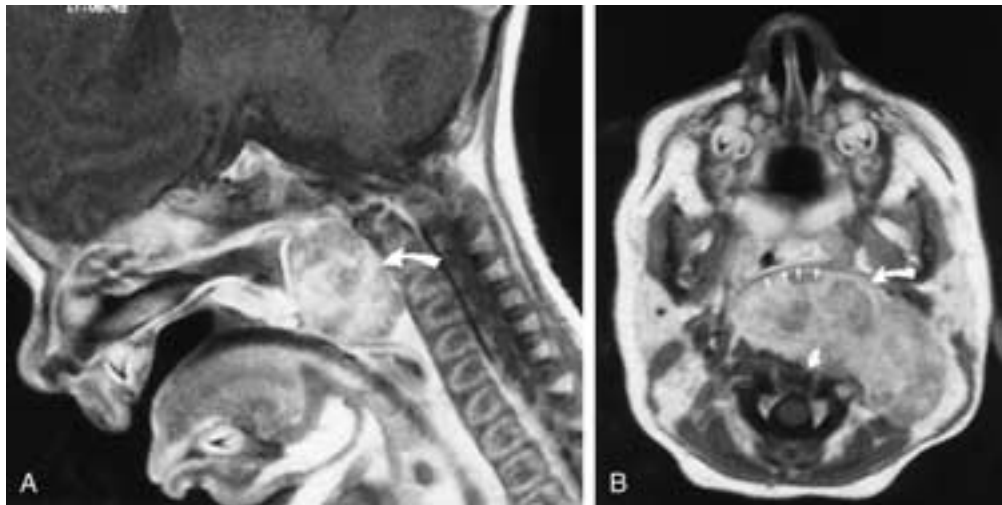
A, Contrast-enhanced T1-weighted MR image demonstrates a large, heterogeneous mass (*curved arrow*) in the posterior aspect of the nasopharynx. Biopsy showed a rhabdoid tumor. B, Axial image shows that the mass (*large curved arrow*) extends into the lateral compartment of the neck. There is erosion of the anterior portion of the vertebral body (*small curved arrow*) and anterior displacement of the posterior pharyngeal wall (*small straight arrows*).
